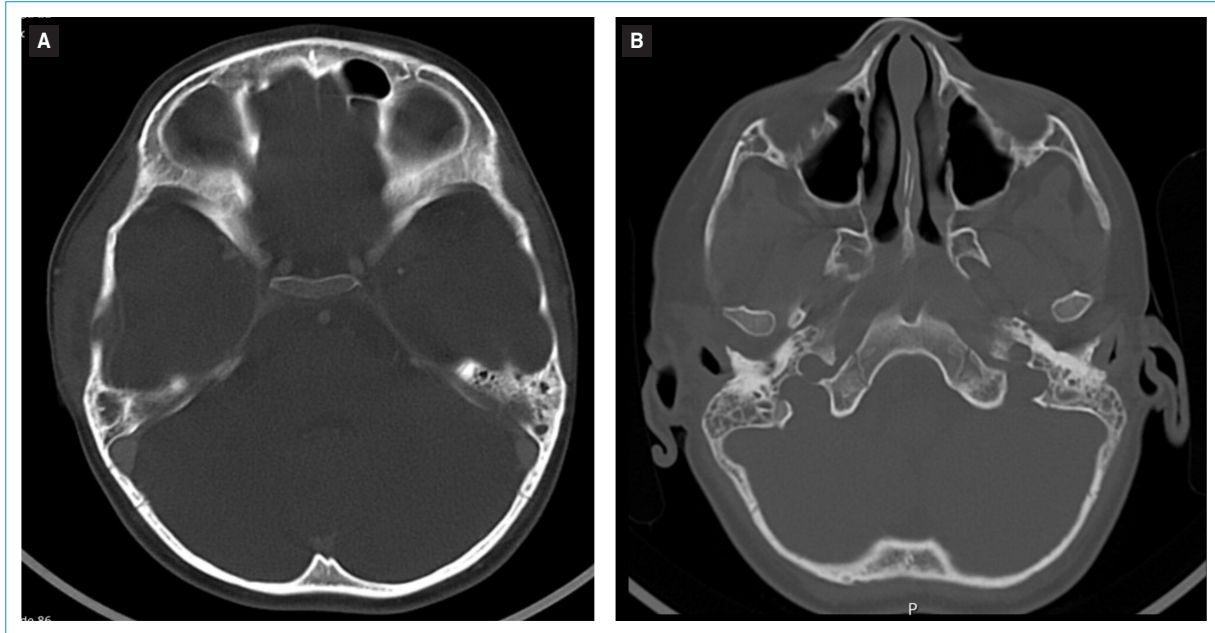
CT scans. Case 2 — Axial CT images show a collection beneath the temporal muscle with erosion of the temporal squama and a contiguous extra-axial intracranial empyema (A). Despite bilateral mastoid opacification, no bony erosion is evident within the mastoid (B).
